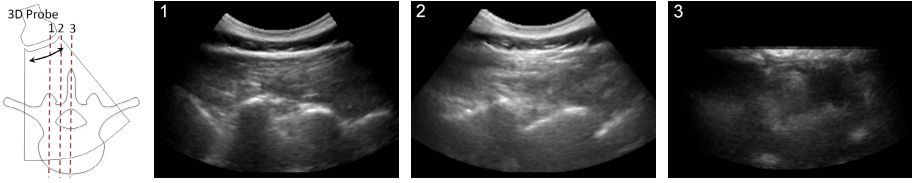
Three parallel slices extracted from the 3D ultrasound image. Arrow shows the sweep direction. Planes are spaced 10 mm from each other. Ideally, the anesthesiologist should perform the needle injection in the third plane which does not include strong features. The first plane shows the facet joints whereas the second plane shows the laminae. The planes are also hard for novice users to distinguish the anatomy in the ultrasound, making needle guidance difficult.
